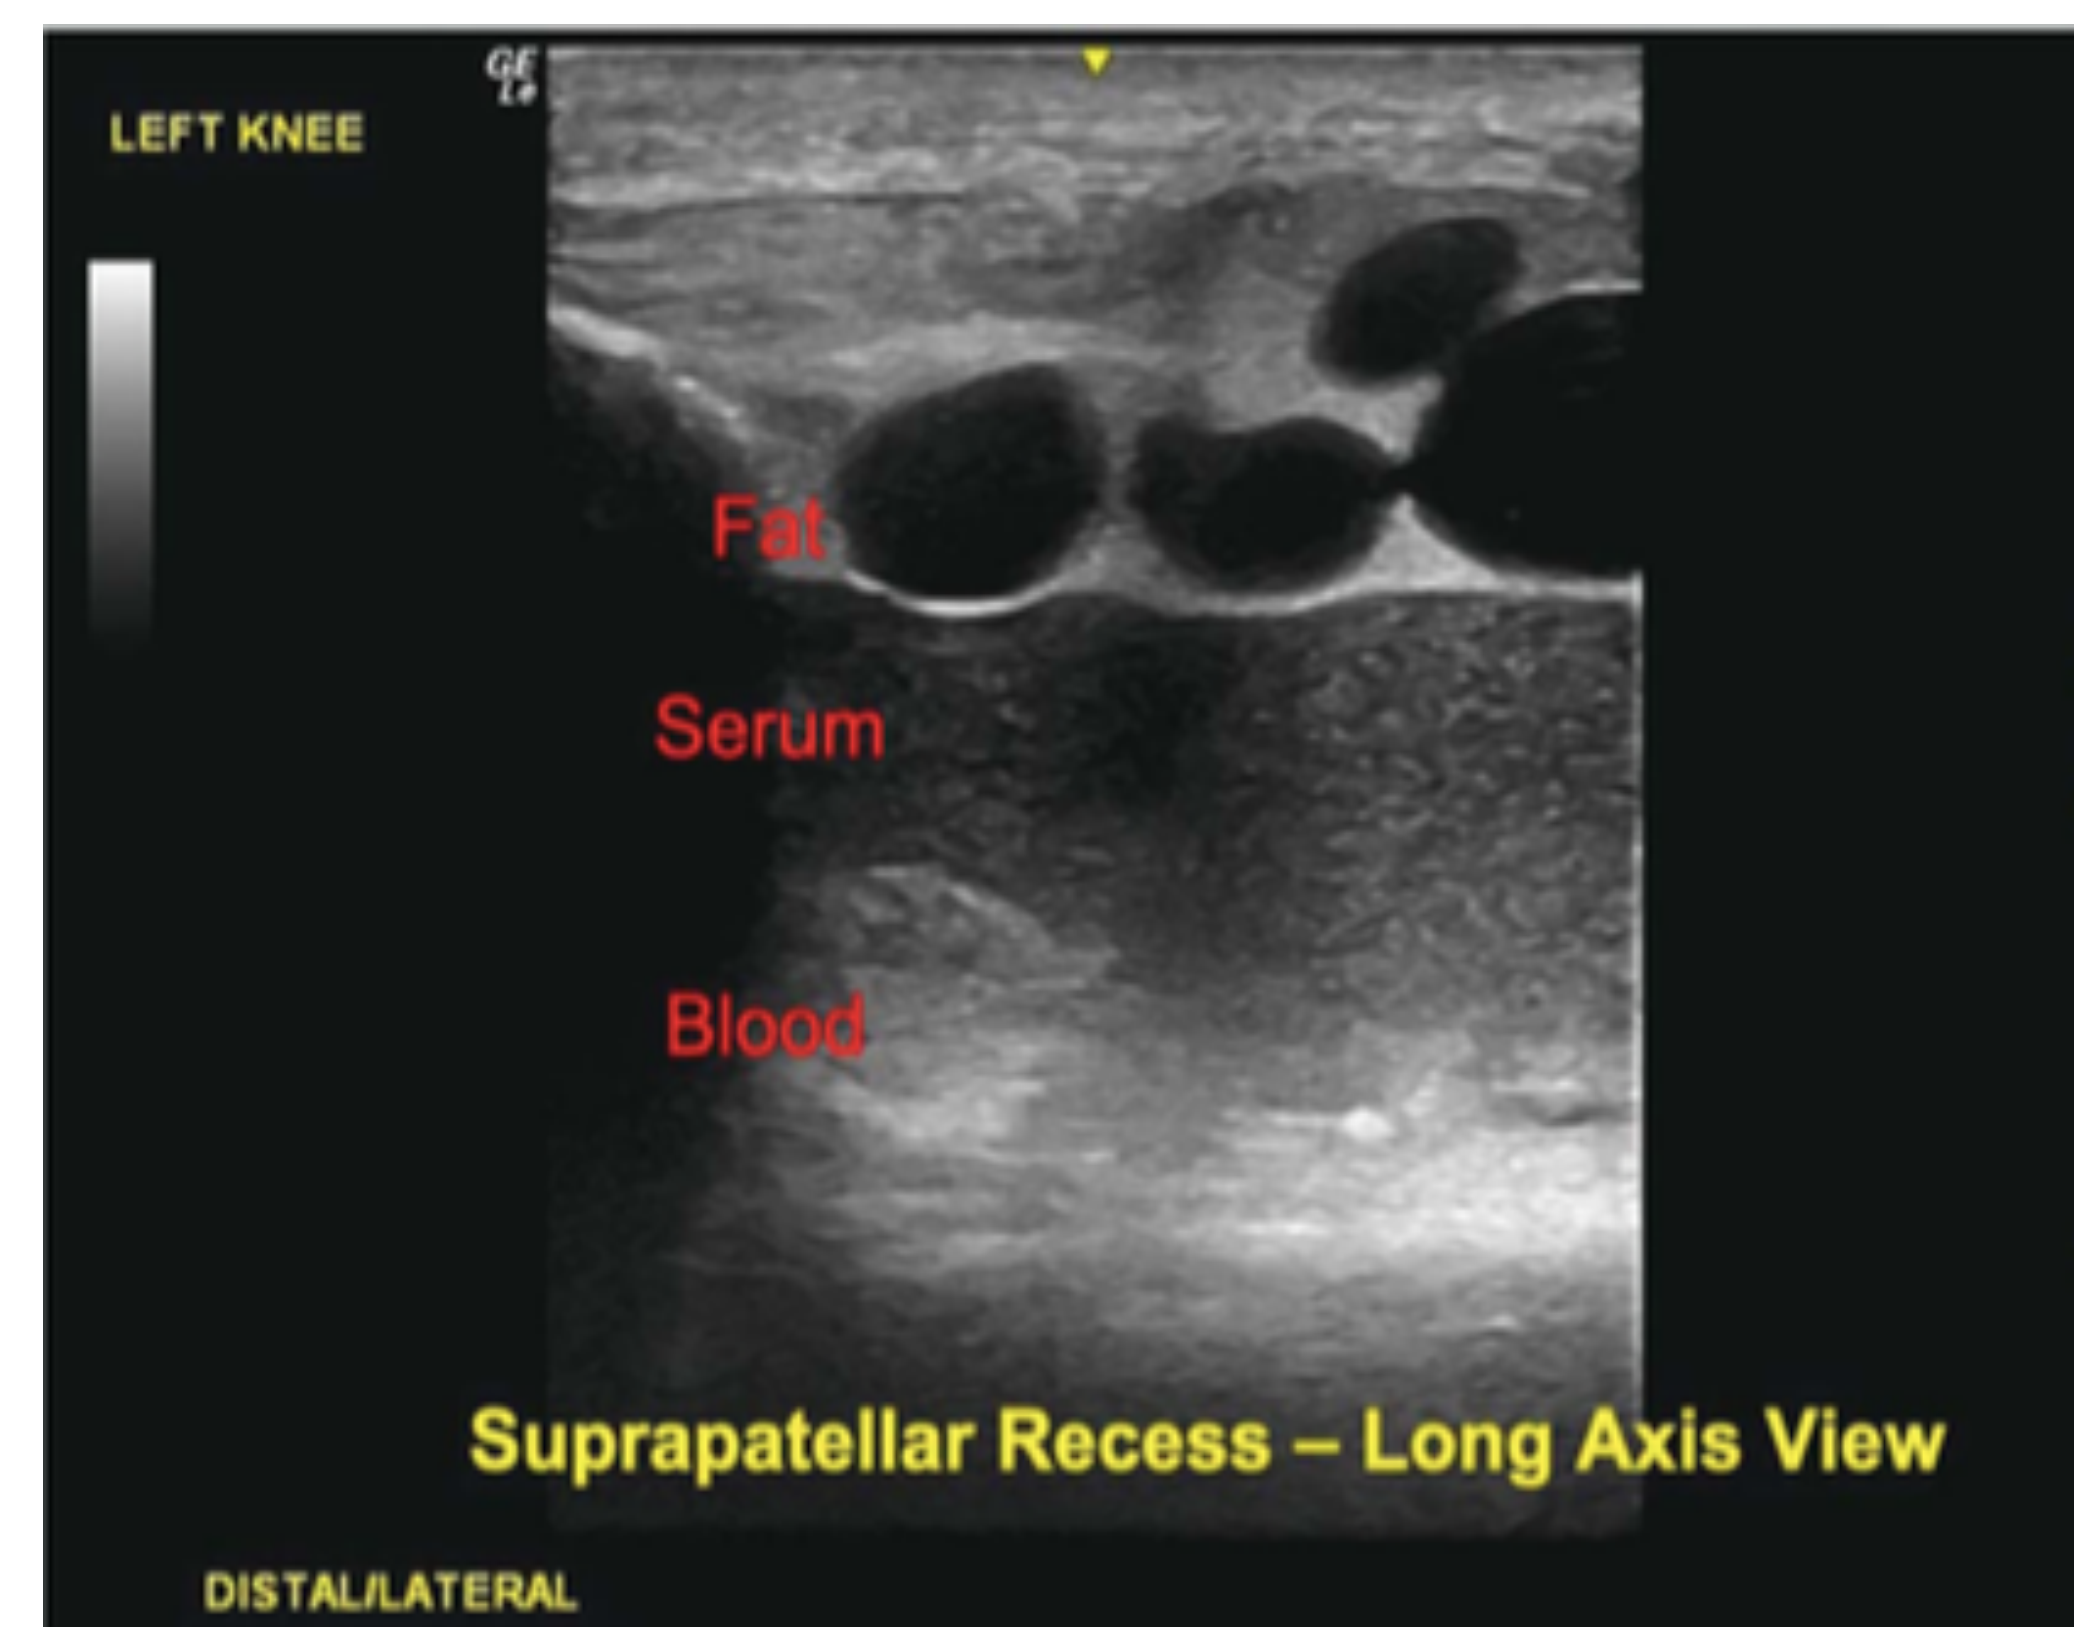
Ultrasound image of the left suprapatellar recess in an anatomical longitudinal view showing three distinct layers, from superficial to deep, of fat, plasma, and red blood cells, as indicated on the image.
